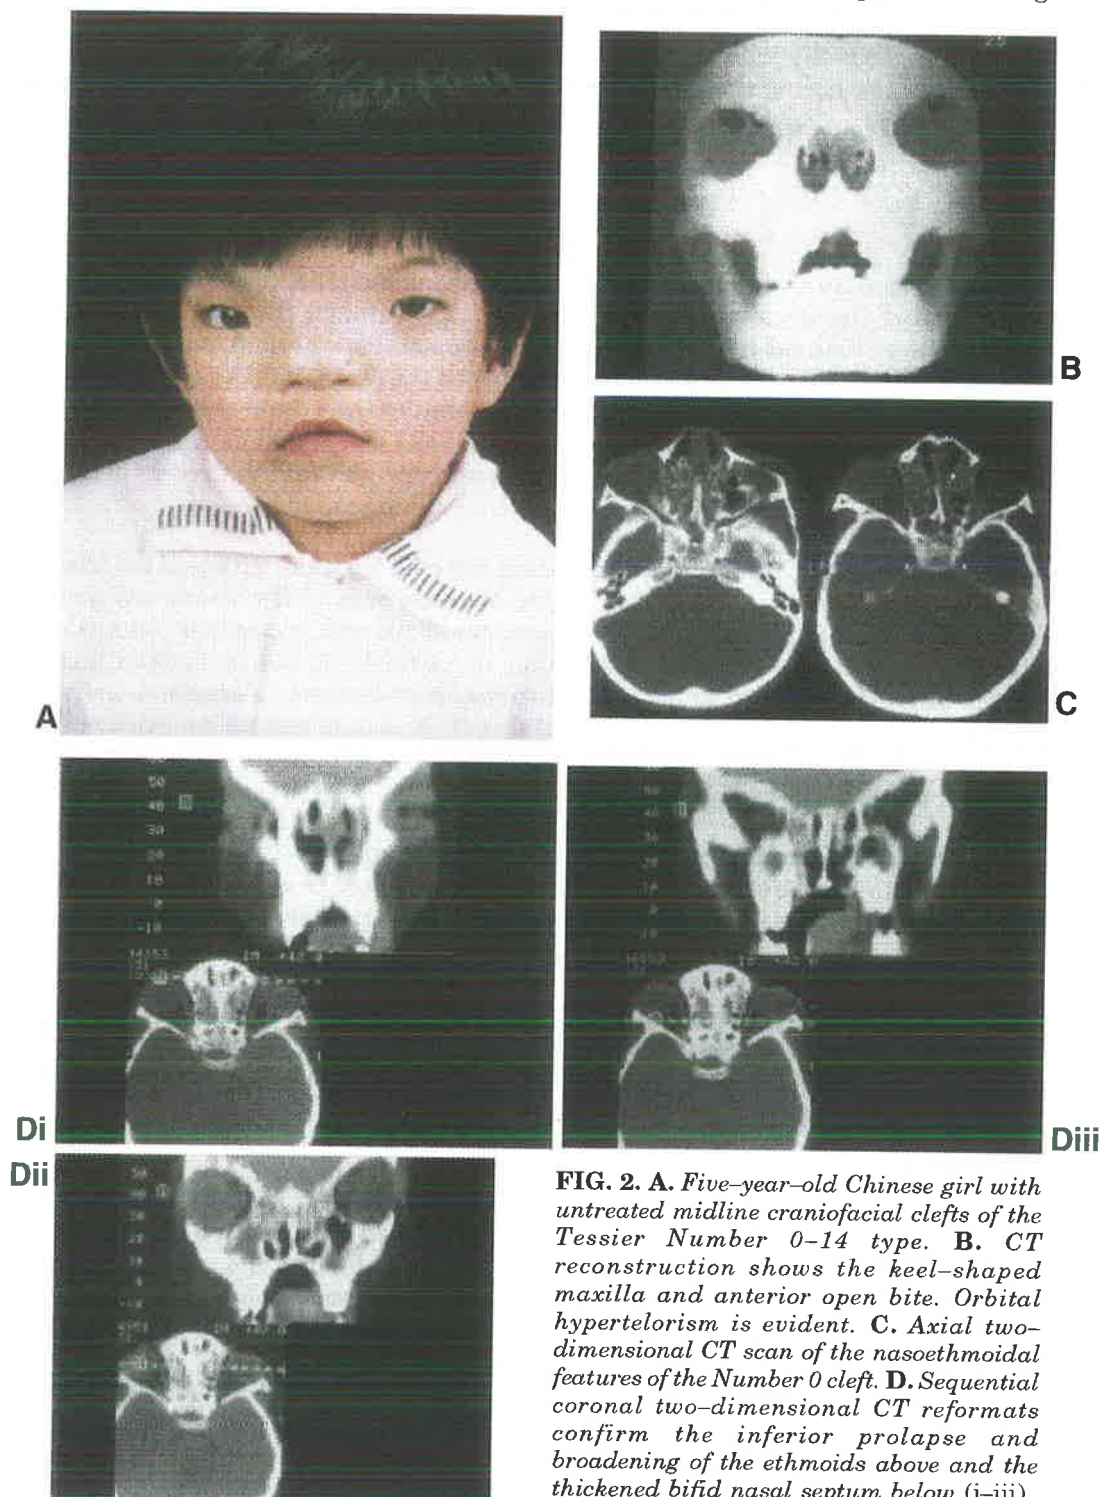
A. Five-year-old Chinese girl with untreated midline craniofacial clefts of the Tessier Number 0-14 type. B. CT reconstruction shows the keel-shaped maxilla and anterior open bite. Orbital hypertelorism is evident. C. Axial two-dimensional CT scan of the nasoethmoidal features of the Number 0 cleft. D. Sequential coronal two-dimensional CT reformats confirm the inferior prolapse and broadening of the ethmoids above and the thickened bifid nasal septum below (i-iii).
